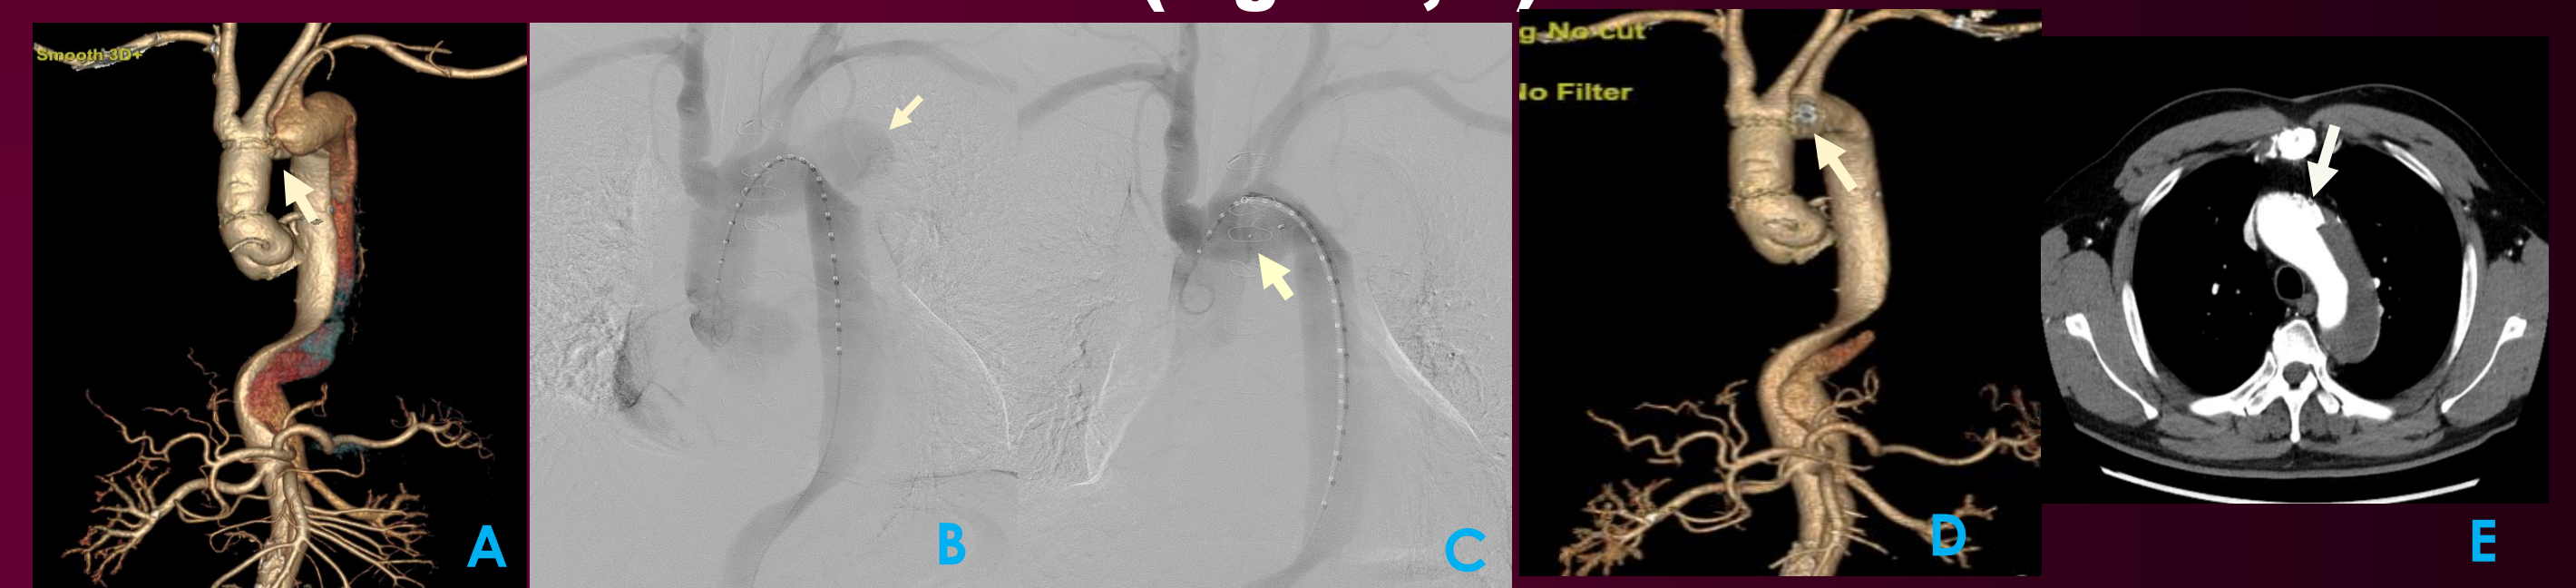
A. Computed tomography angiography shows aortic anastomotic leak in the aortic arch (arrow).D. MIP image shows a pseudoaneurysm and severe atherosclerotic change.
